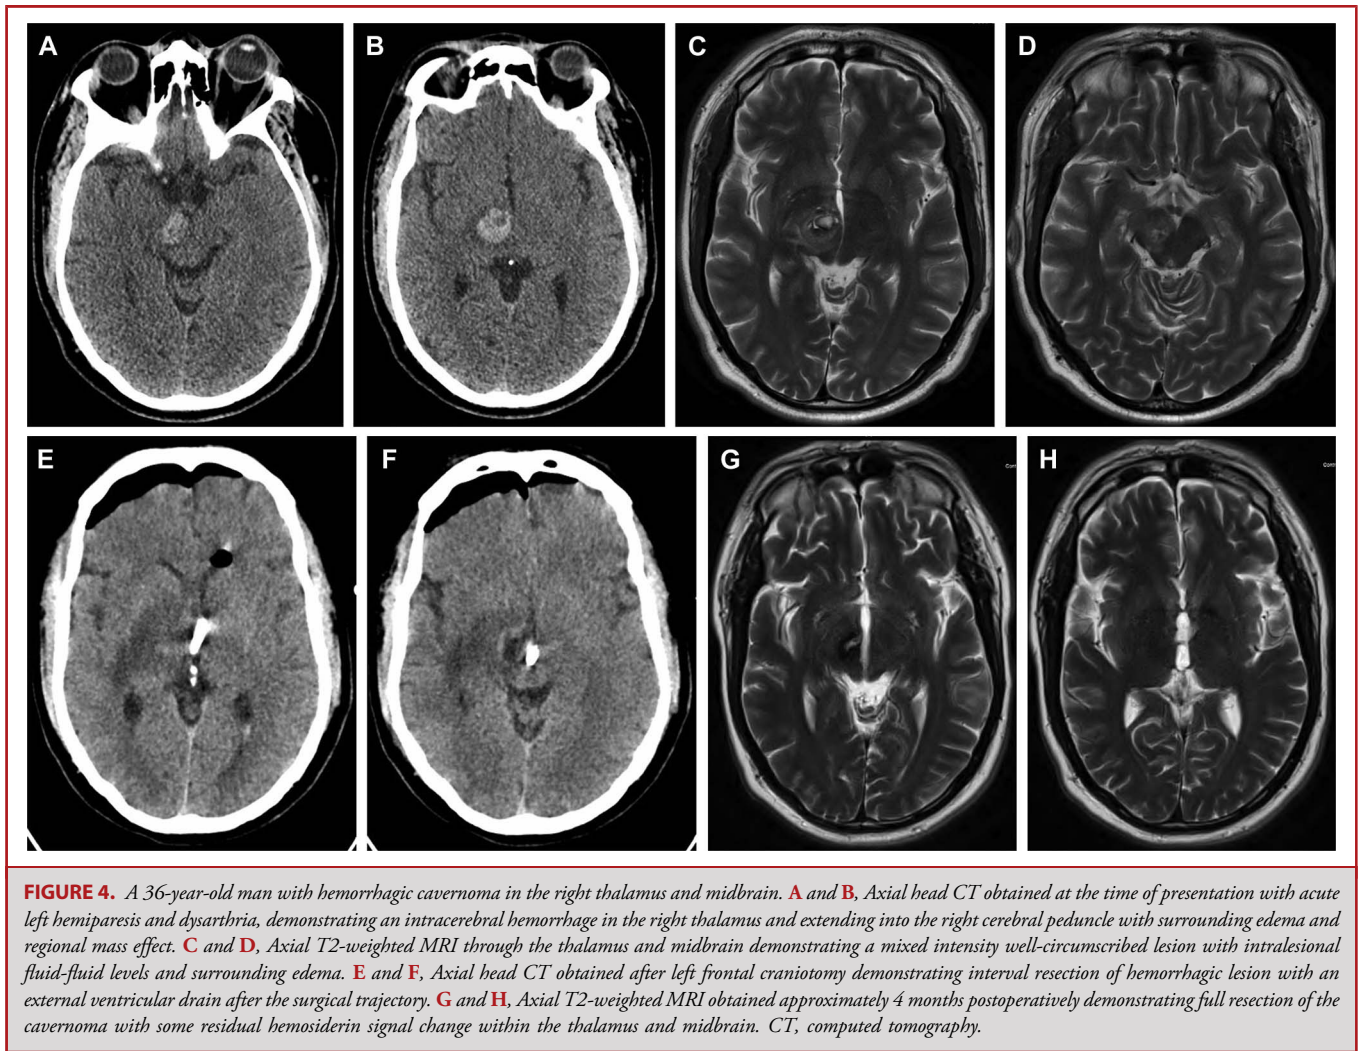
A 36-year-old man with hemorrhagic cavernoma in the right thalamus and midbrain. A and B, Axial head CT obtained at the time of presentation with acute left hemiparesis and dysarthria, demonstrating an intracerebral hemorrhage in the right thalamus and extending into the right cerebral peduncle with surrounding edema and regional mass effect. C and D, Axial T2-weighted MRI through the thalamus and midbrain demonstrating a mixed intensity well-circumscribed lesion with intralesional fluid-fluid levels and surrounding edema. E and F, Axial head CT obtained after left frontal craniotomy demonstrating interval resection of hemorrhagic lesion with an external ventricular drain after the surgical trajectory. G and H, Axial T2-weighted MRI obtained approximately 4 months postoperatively demonstrating full resection of the cavernoma with some residual hemosiderin signal change within the thalamus and midbrain. CT, computed tomography.
